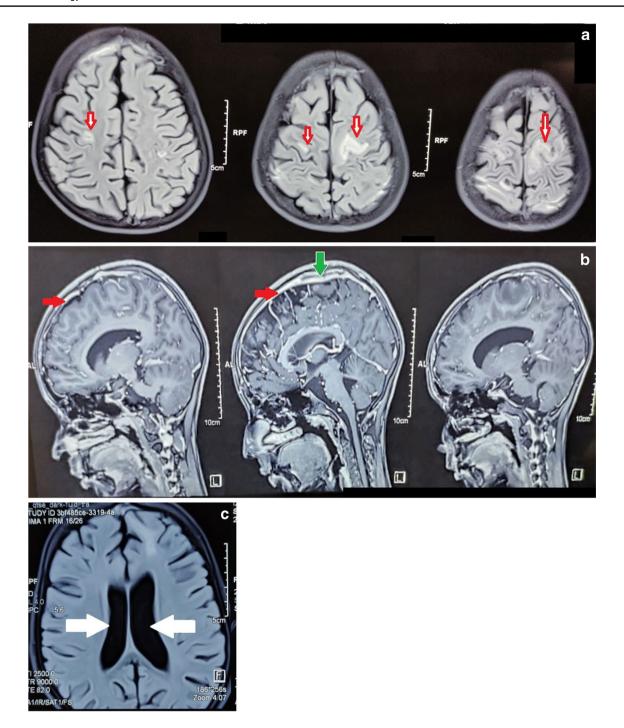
MRI brain with contrast showing multiple areas of focal oedema in frontal and parietal regions (A), diffuse meningeal enhancement (red arrow) with cerebral venous sinus thrombosis
